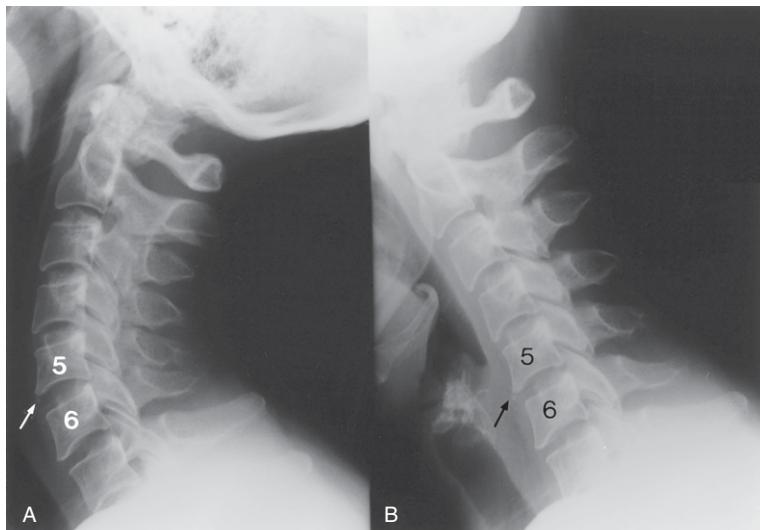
(A) Cervical spine extension plain X-ray image which shows a small calcific density adjacent to the inferior endplate of C5 anteriorly (white arrow). Also, the disc height is increased anteriorly at C5–6 compared to the discs at C4–5 and C6–7 levels, suggesting weakness of the anterior annular fibres and perhaps an injury to the anterior longitudinal ligament at C5–6. The disc height posteriorly at C6–7 is greater than the disc height anteriorly, raising the possibility of injury posteriorly to the intervertebral disc and the posterior longitudinal ligament at this level. In addition, note the slight retrolisthesis of the C3 body on the C4 body. (B) Cervical spine flexion image showing the calcific density described above (black arrow). Note how this structure changes its position on extension and flexion. Also, note that there is an angulation at the C4–5 level with the vertebral bodies below this level aligned in an almost straight line, particularly from C5 to C7, indicating limited movement below the C4 level.
